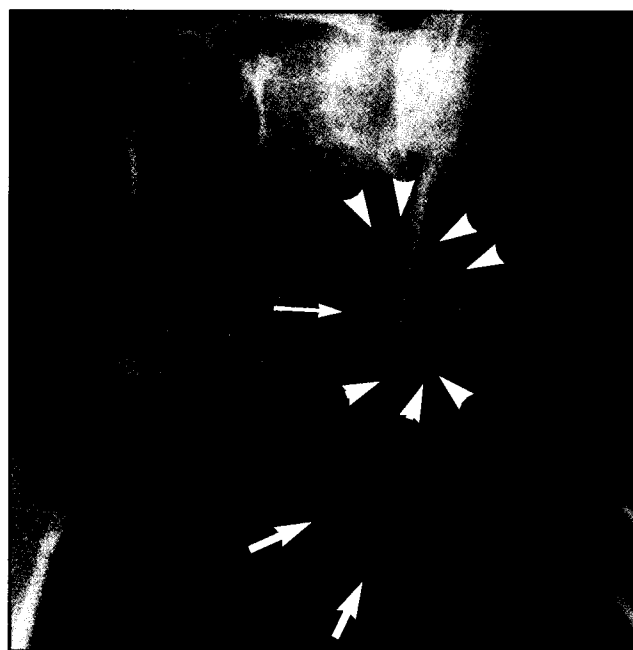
Ventrodorsal radiograph of the pelvis showing fracture malunion of a free acetabular segment with fractures of the ilium (arrow heads), pubis (small arrow) and ischium (large arrows).
